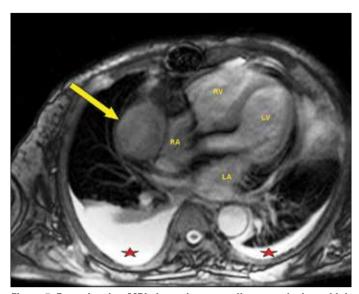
Four-chamber MRI showed extracardiac mass lesion which compress right atrium (yellow arrow) and bilateral pleural effusion (red asterix) with compression atelectasis in lower lobe of right lung LA - left atrium, LV - left ventricle, MRI - magnetic resonance imaging, RA - right atrium, RV - right ventricle
